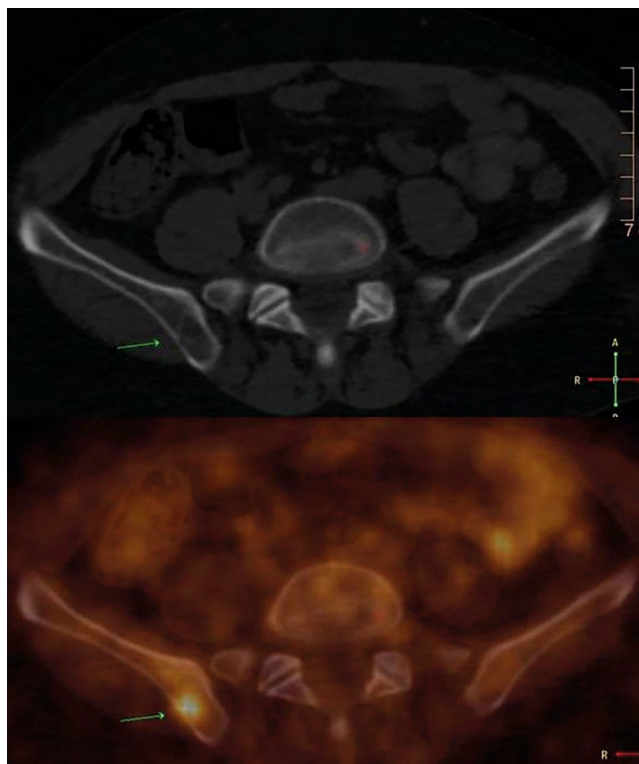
A patient with CM of the right thorax, pT4b cN0 cM0. The patient had right axillar LNs recurrence, staged pT4 pN2b M0 after the radical treatment. A follow-up [¹⁸F]FDG PET/CT study was performed 4 months after the first recurrence where a right iliac lesion was found, indistinguishable on CT
